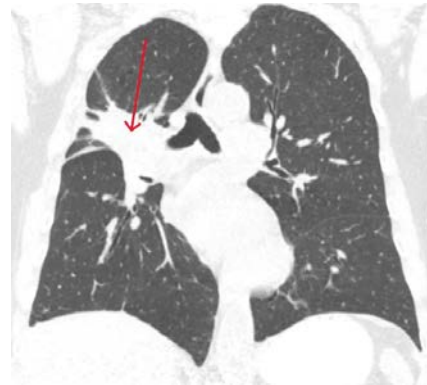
Coronal plane of the chest, computed tomography scan: the arrow indicates a tumor lesion in the upper right lobe with infiltration and compression of the main bronchus.
